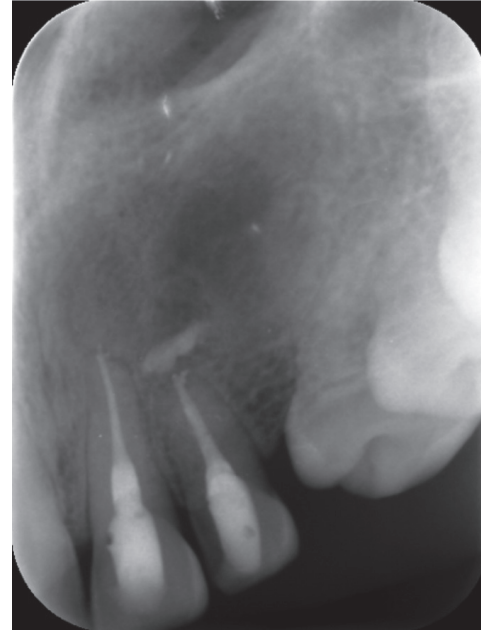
Periapical radiograph 17 months after surgery.
